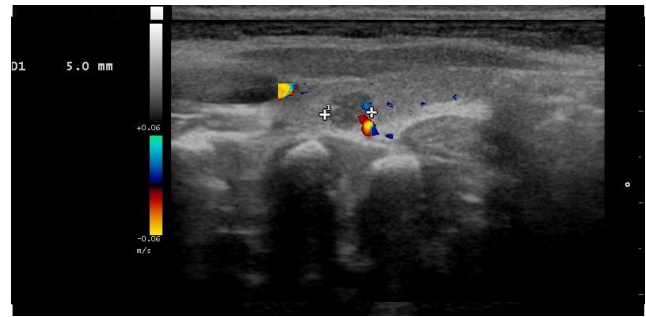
Right longitudinal color-Doppler ultrasound image of the neck. A hypoechoic heterogeneous and well-demarcated lesion with punctate echogenic foci and peripheral vascularity is seen at the upper pole of the right thyroid (maximum diameter: 5mm).
